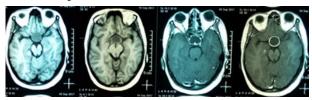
MRI axial (T1 & T1 with contrast) showing recurrent sellar abscess.
